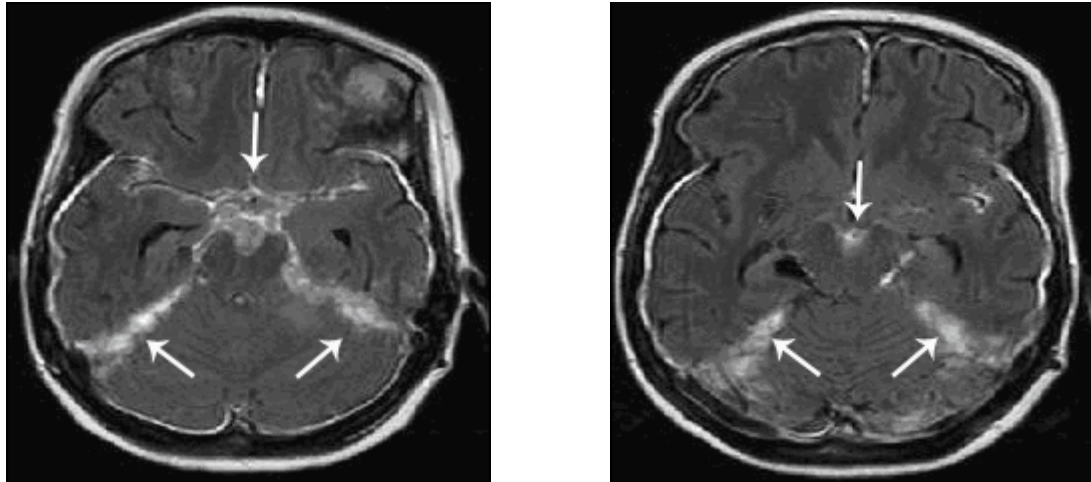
Sample MR images of meningitis used in the study
